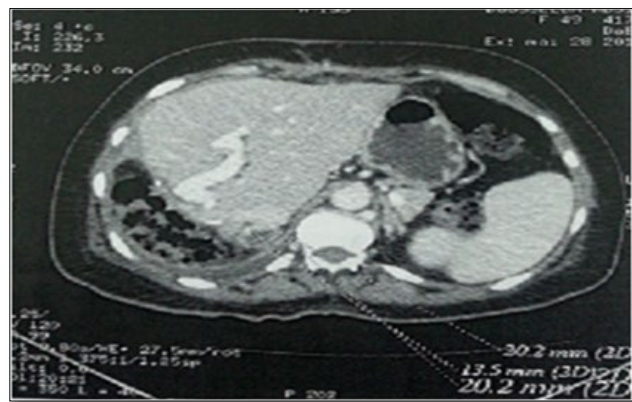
CT scan of case 2 demonstrating an enlarged right adrenal gland with a low density area.
